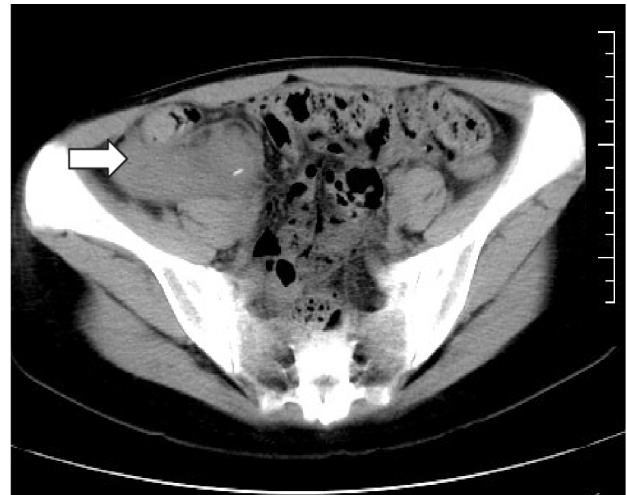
Abdominal computed tomography (CT) scan showing an abscess around the cecum (white arrow), which measured 50×30 mm² in size, but the appendix could not be detected.
